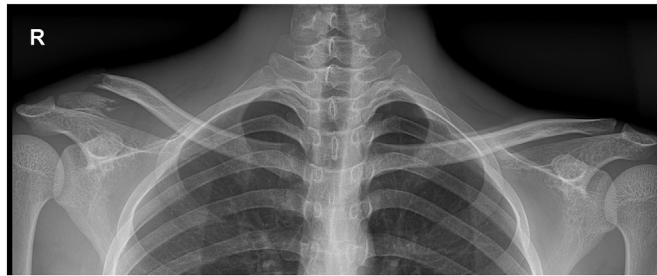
Preoperative anteroposterior radiograph of the both clavicle showing the distal fracture of right clavicle.
